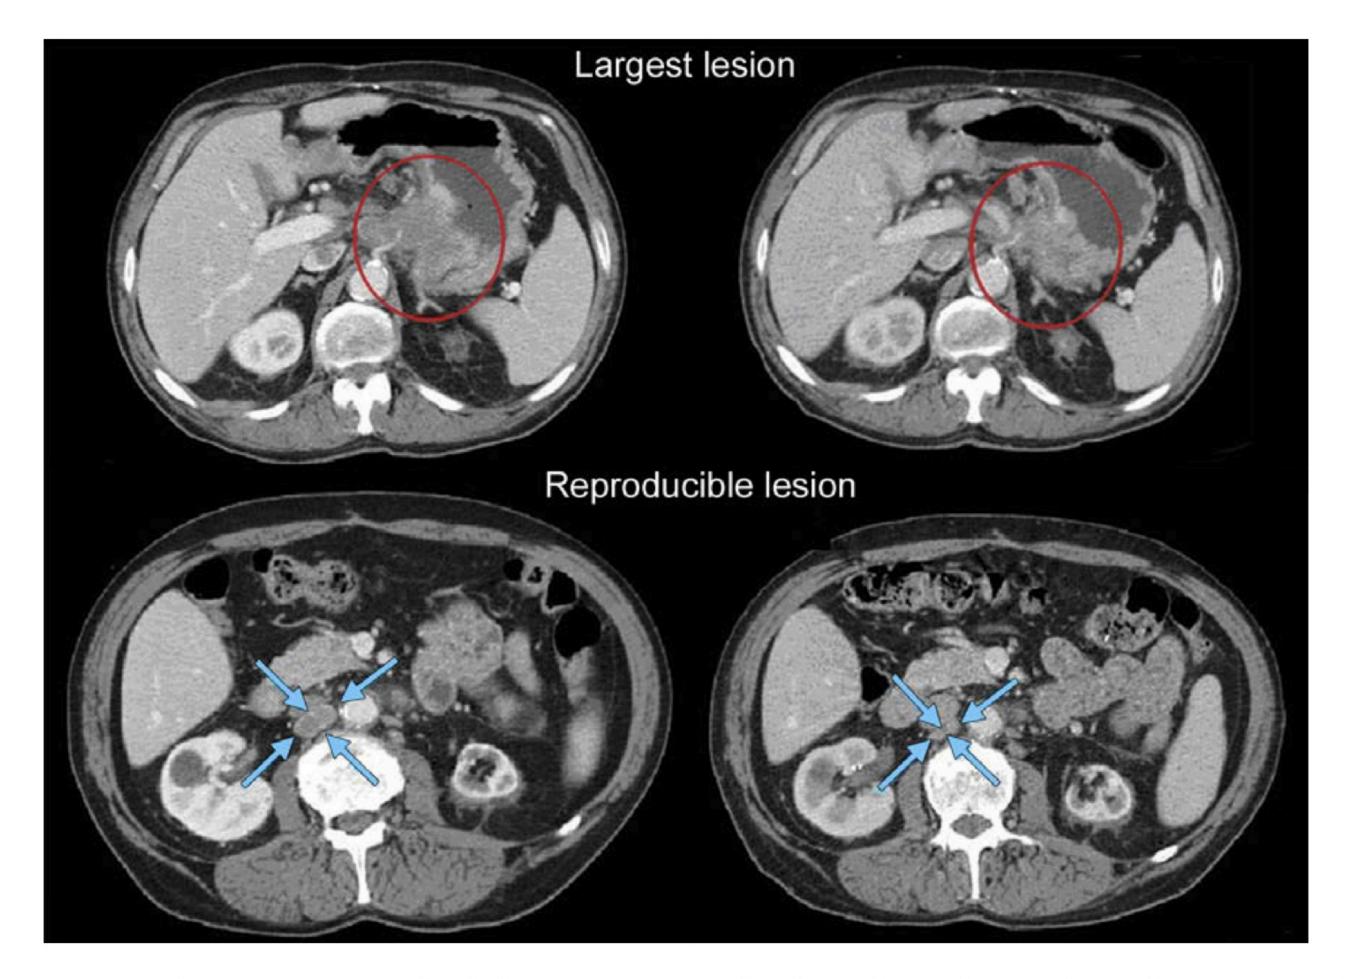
Largest lesion may not be most reproducible: most reproducible should be selected as target. In this example, the primary gastric lesion (circled at baseline and at follow-up in the top two images) may be able to be measured with thin section volumetric CT with the same degree of gastric distention at baseline and follow-up. However, this is potentially challenging to reproduce in a multicentre trial and if attempted should be done with careful imaging input and analysis. The most reproducible lesion is a lymph node (circled at baseline and at follow-up in the bottom two images).
